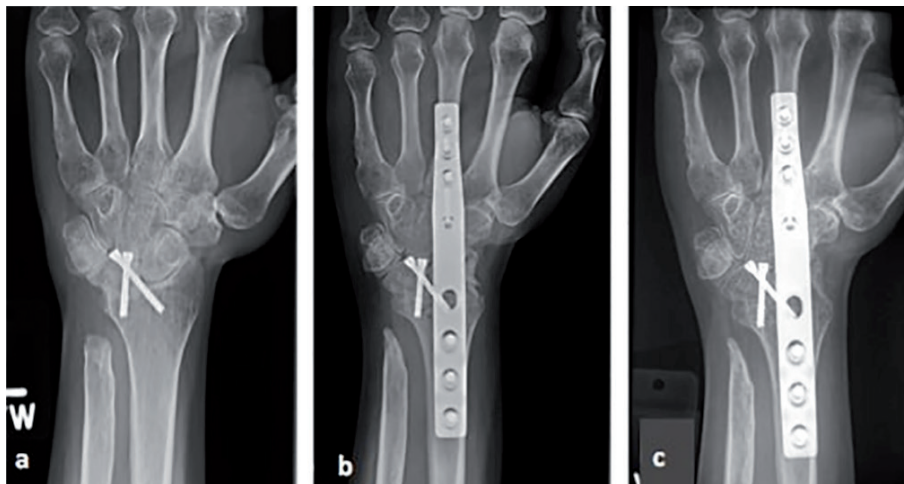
Radiographs of a patient who underwent a total wrist arthrodesis as a reoperation after a Darrach procedure.
